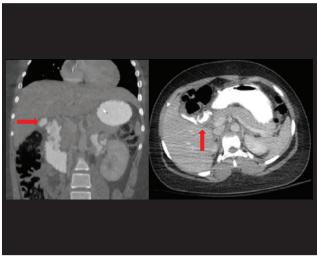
Abdominal CT (sagittal and coronal planes) showing contrast and air in biliary tree (arrows) consistent with a CDF.
